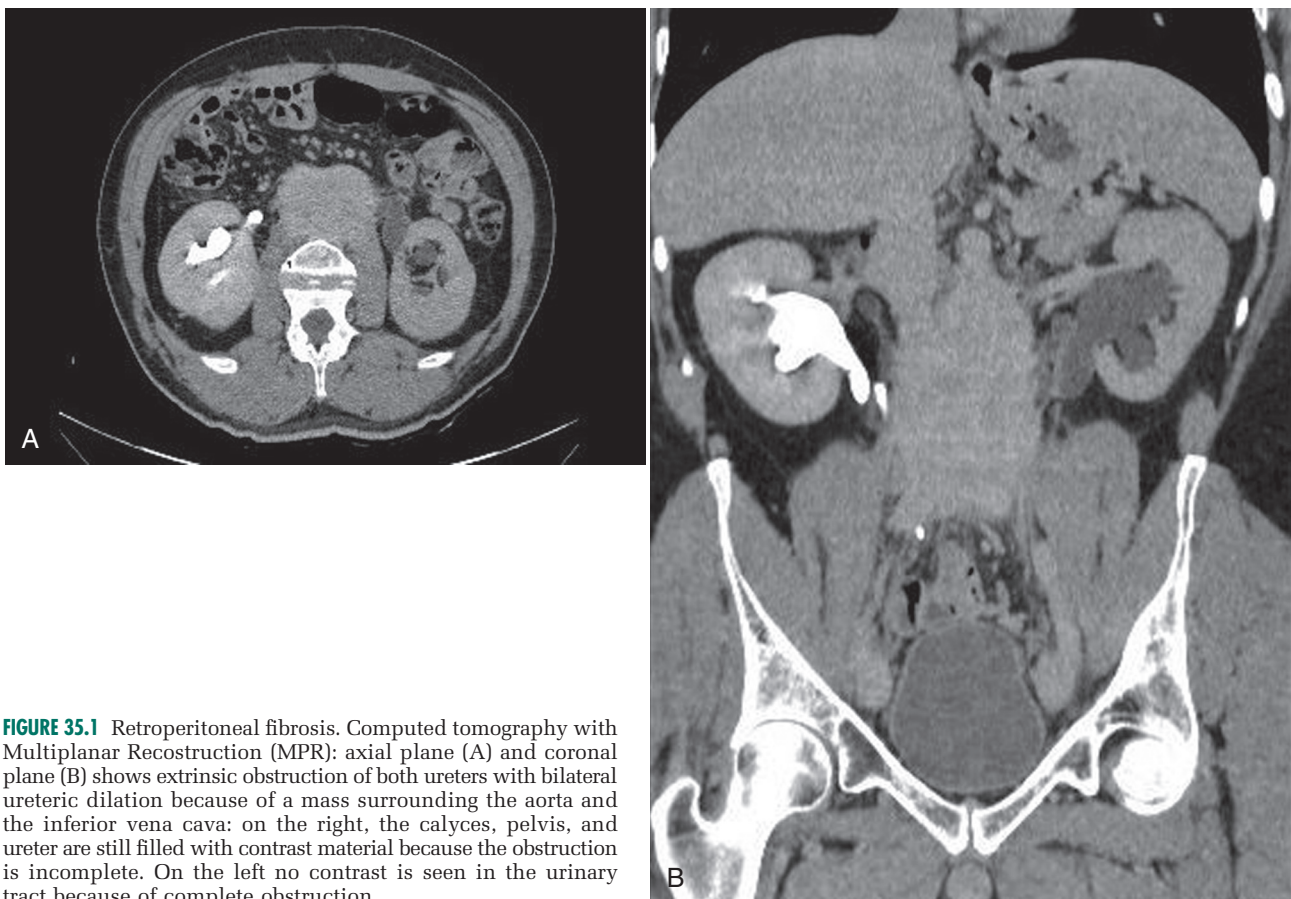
Retroperitoneal fibrosis. Computed tomography with Multiplanar Reconstruction (MPR): axial plane (A) and coronal plane (B) shows extrinsic obstruction of both ureters with bilateral ureteric dilation because of a mass surrounding the aorta and the inferior vena cava: on the right, the calyces, pelvis, and ureter are still filled with contrast material because the obstruction is incomplete. On the left no contrast is seen in the urinary tract because of complete obstruction.
